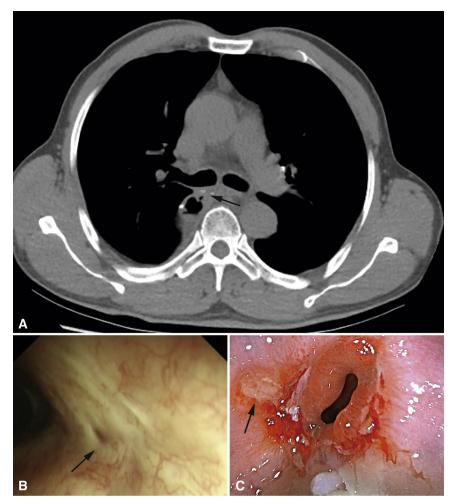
Examinations performed after stent removal. A, Axial CT image performed 1 week after stent removal showed that the fistula was healed (*black arrow*). B, Bronchoscopy and C, gastroscopy showed the well-healed fistula without recurrence 13 months after stent removal (*black arrow*).
